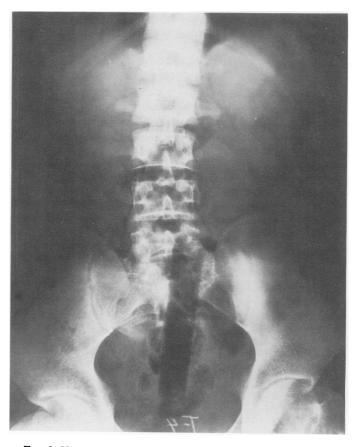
X-ray appearance of a rectangular toothbrush package.
